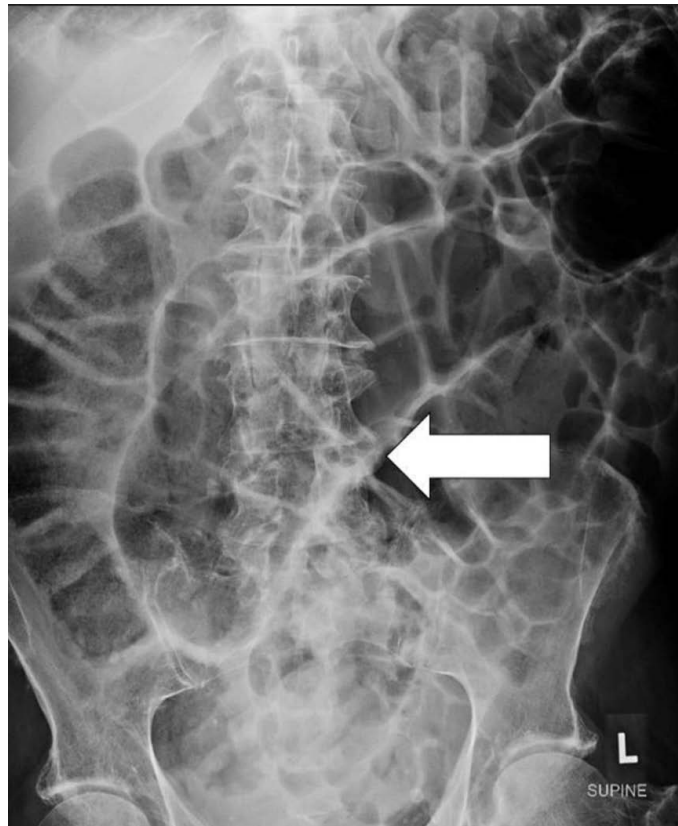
Supine abdominal radiograph demonstrated dilated large bowel loops (arrow).
